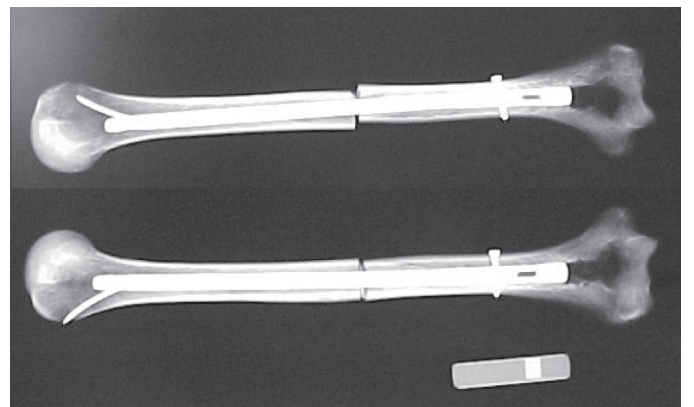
X-ray image of the intramedullary nail assembly.
